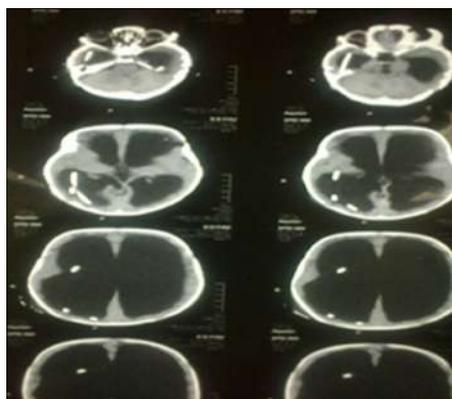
(a): CT scan brain axial slices showing hydrocephalous and right side VP shunt in initial stages.
